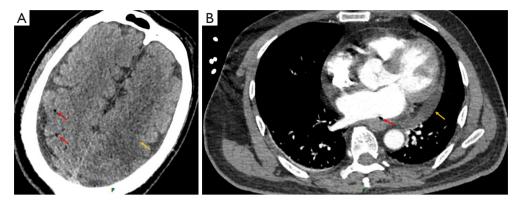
Imaging of atrial-esophageal fistula on brain and chest CT. (A) Brain CT showed a large area of left craniocerebral infarction (red arrow) and air emboli in the right lobe (yellow arrow). (B) Chest CT demonstrated air between the left atrium and esophagus (red arrow), as well as pericardial effusions (yellow arrow). CT, computed tomography.
